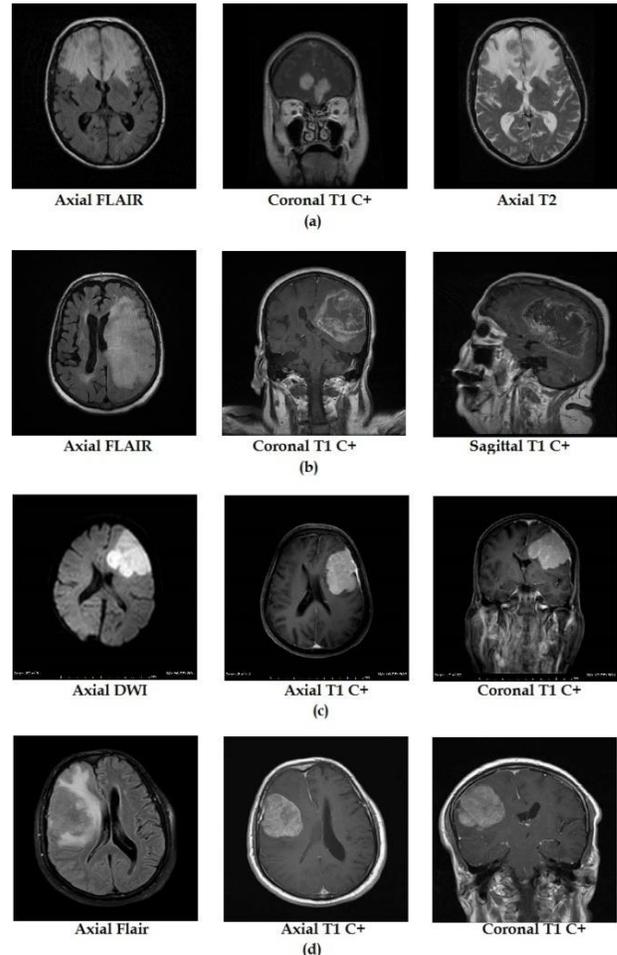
Sample of MRI Modalities and Tumor Types used in our proposed dataset
